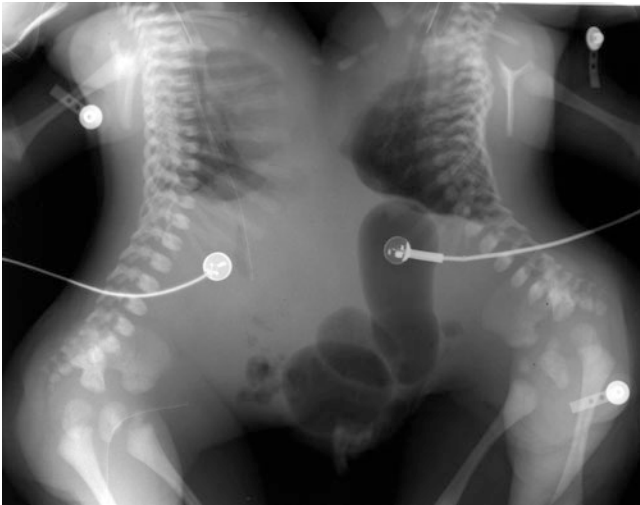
Plain X-ray showing conjoined twins sharing abdominal contents
